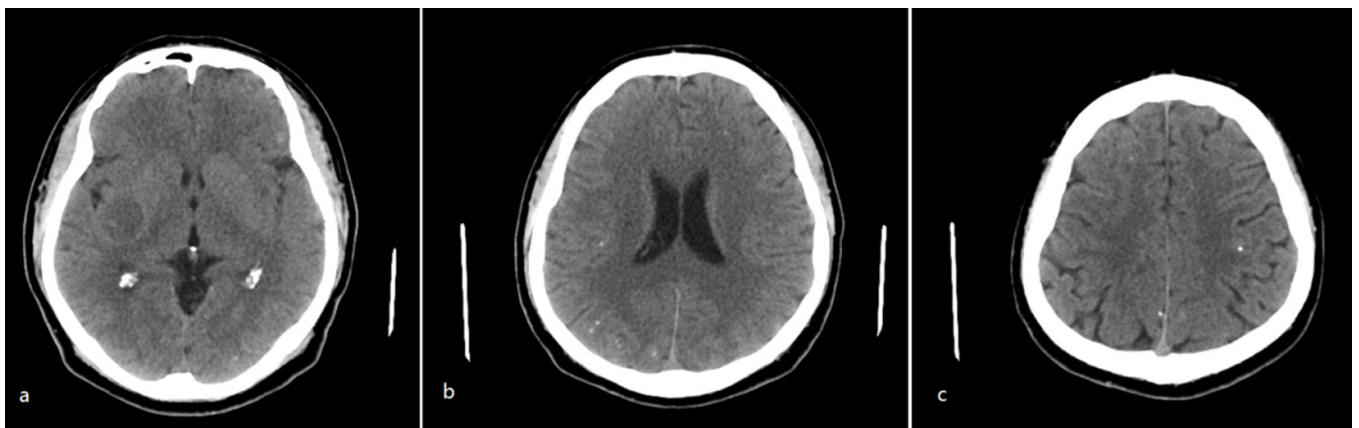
Computed tomography after 2 cycles of treatment with albendazole. There was a single large hypointense cyst in the right basal ganglion region (a) and the resolution of other cysts associated with calcification around the lateral ventricles (b) and in the cerebral cortex(c)
